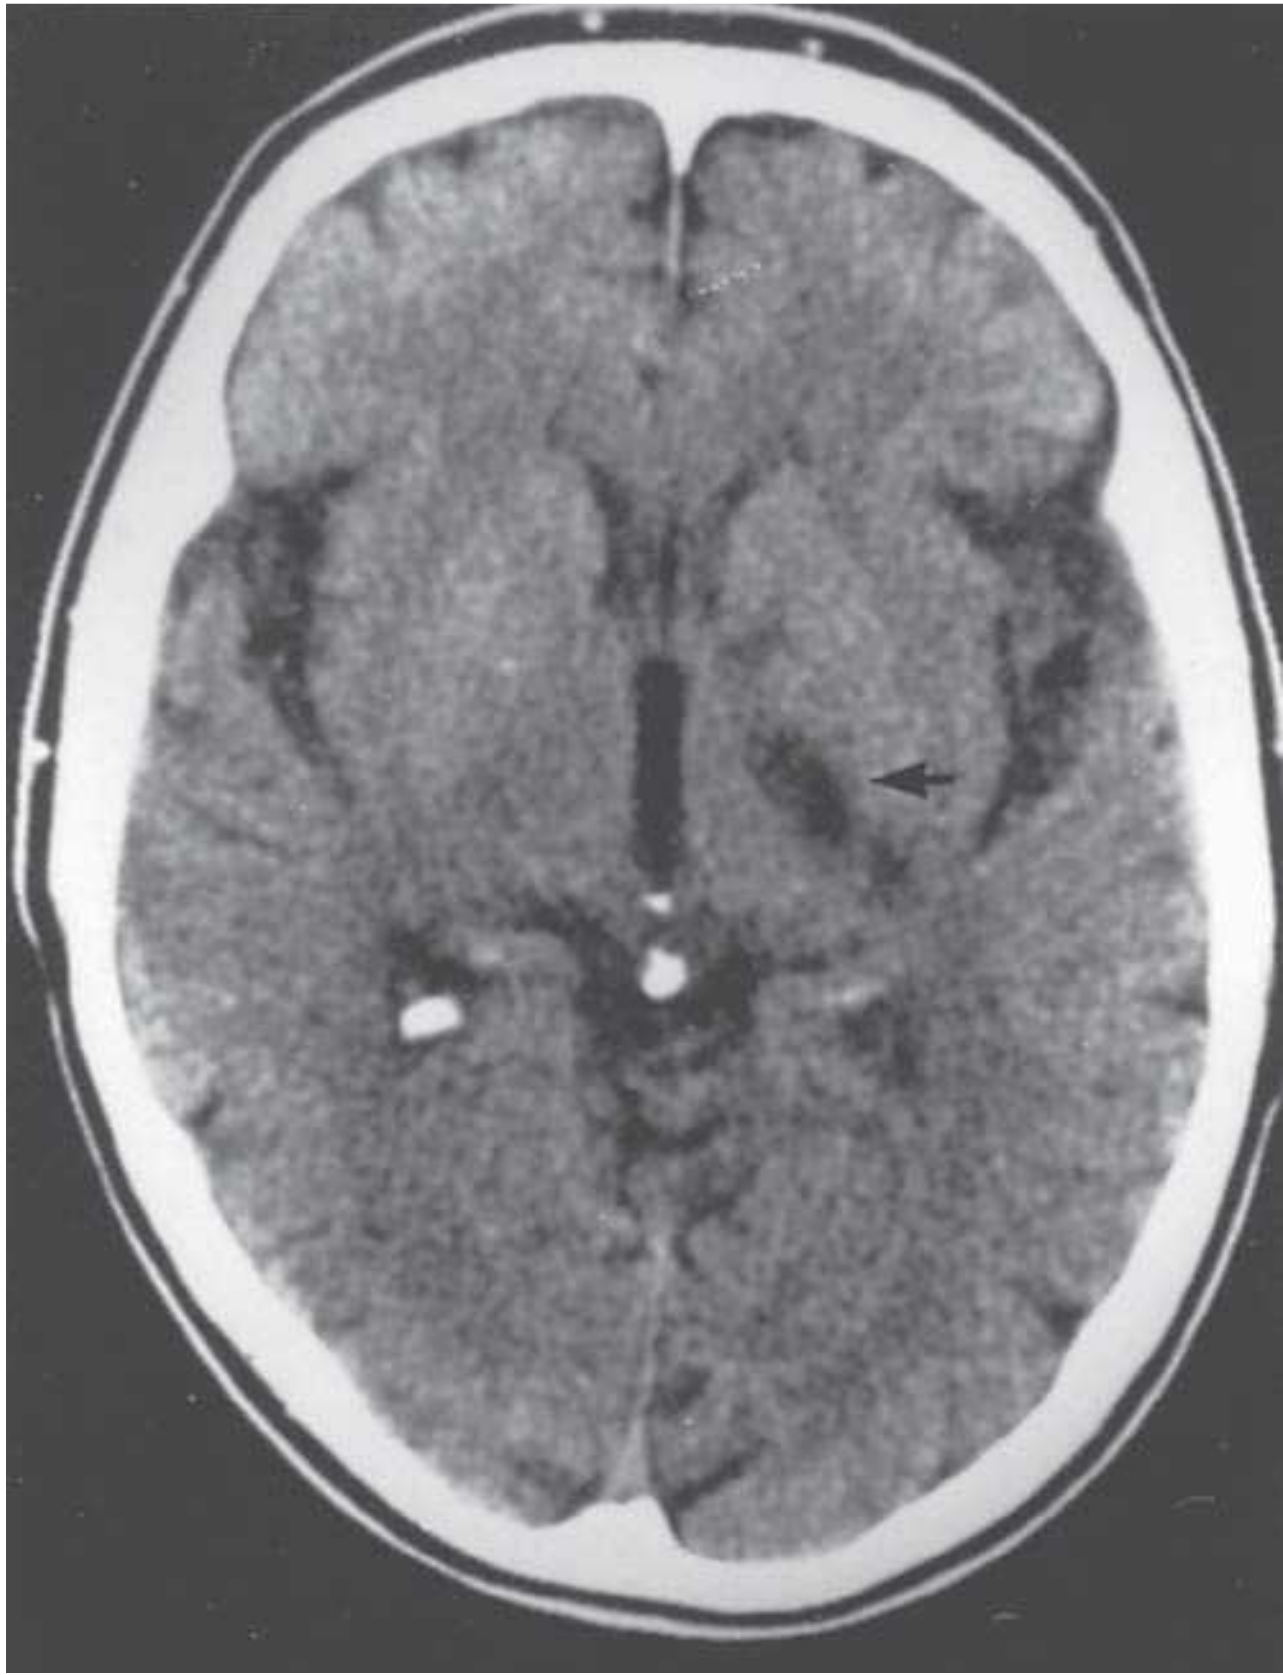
Lacunar infarct involving the left internal capsule seen on a computed tomography scan.
